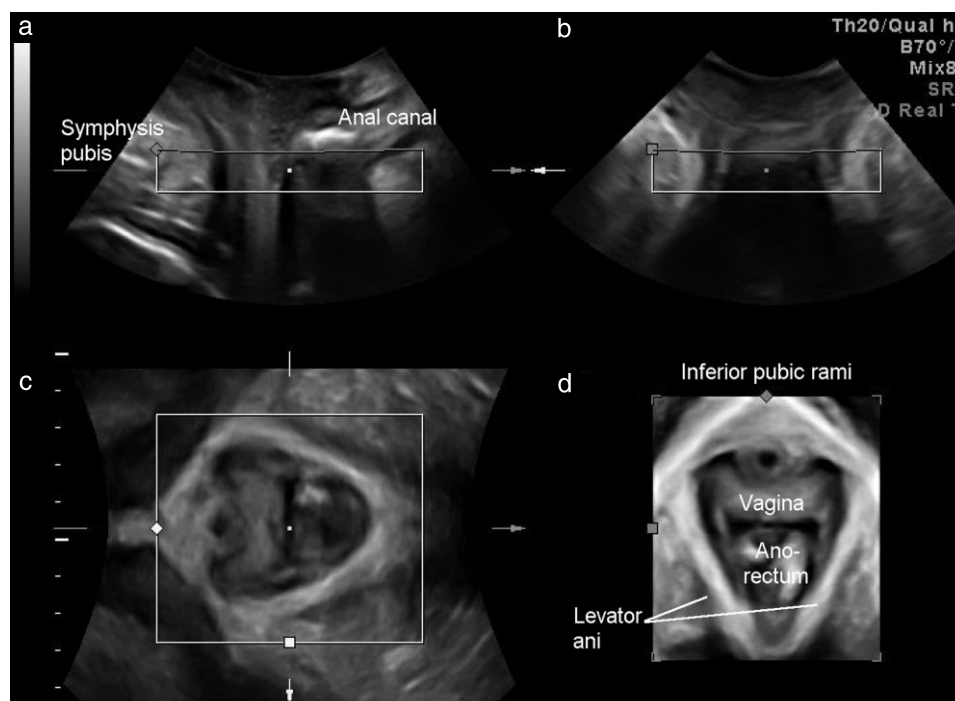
Standard representation of 3D sonography of the pelvic floor. The usual acquisition/evaluation screen on Voluson-type systems shows the three orthogonal planes: sagittal (a), coronal (b) and axial (c) as well as a rendered volume (d), which is a semitransparent representation of all gray-scale data in the rendered volume (i.e. the box visible in (a)–(c)). (From Dietz²⁴ with permission.)
